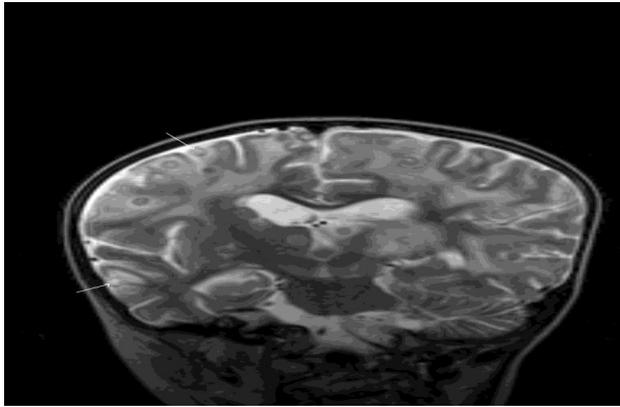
1 – Neurocysticercosis. Coronal T2W MRI shows brain parenchymal and subarachnoid (white arrows) ring lesions with diffuse cerebral edema. This patient also had ventricular lesions (not shown here).
